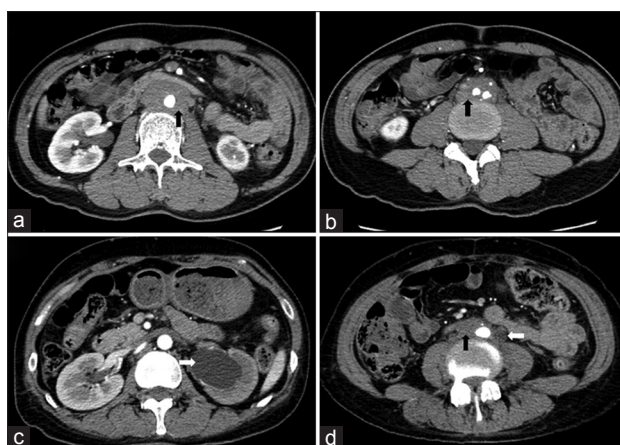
(a and b) The enhanced computed tomography images of a 54-year-old male with retroperitoneal fibrosis showed homogeneous enhancement of low attenuation and relatively smooth peripheral margins of abnormal soft tissue anterior and lateral to aorta with slight anterior displacement of aorta, but the thickest part of the lesion was located in the anterior-lateral aorta (black arrows); and lesion bifurcated and followed common iliac arteries. (c and d) The enhanced computed tomography image of another 61-year-old retroperitoneal fibrosis female showed left obstructive uropathy (white arrows) and soft tissue anterior and lateral to aorta (black arrow).
